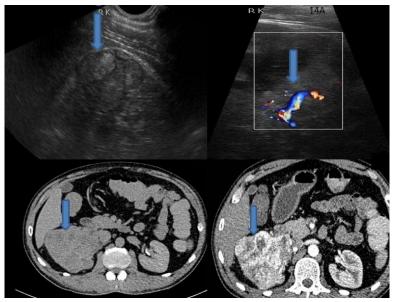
Ill-defined heterogeneous lesion involving right kidney. Color Doppler showing internal vascularity. NECT and CECT images showing heterogeneously enhancing lesion in right kidney showing areas of necrosis.
